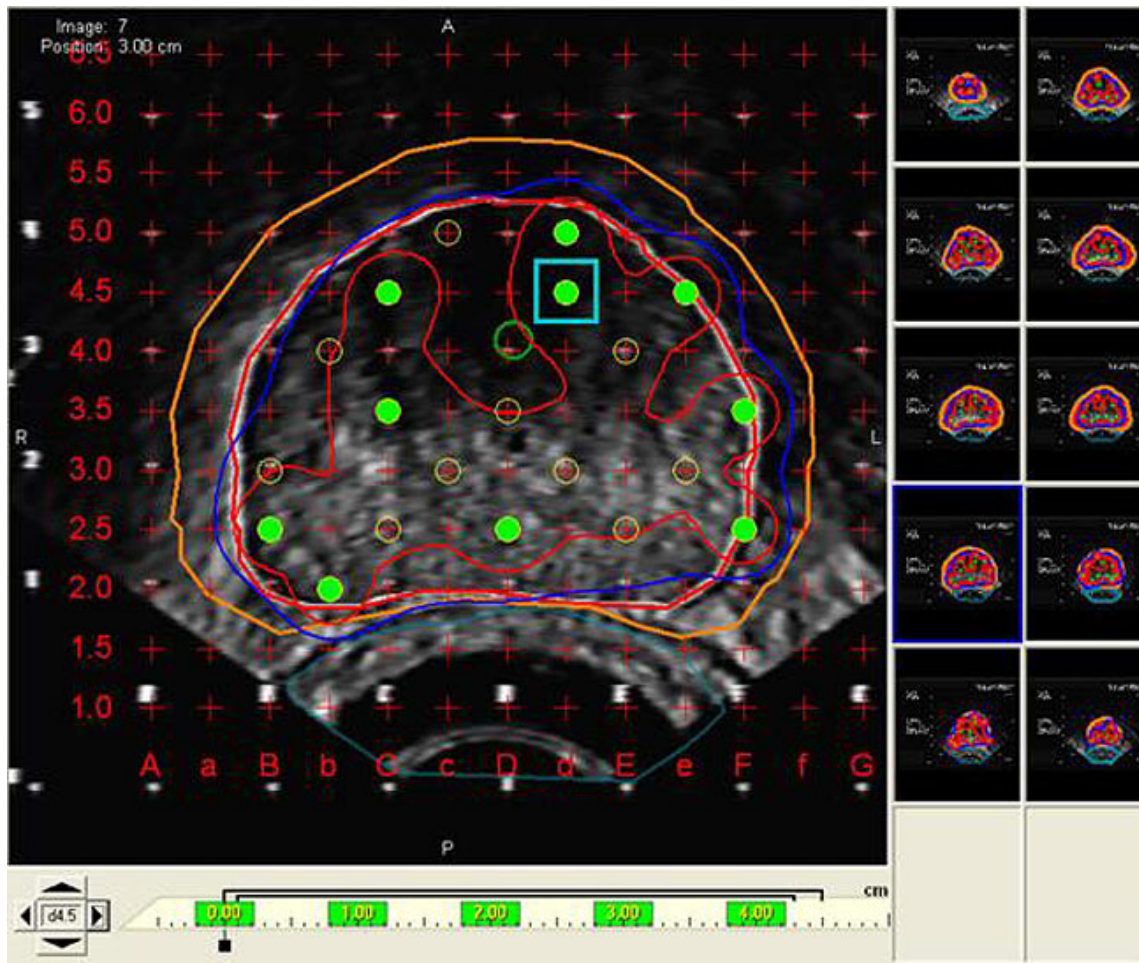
Ultrasound image used for prostate LDR brachytherapy computerized treatment planning.
